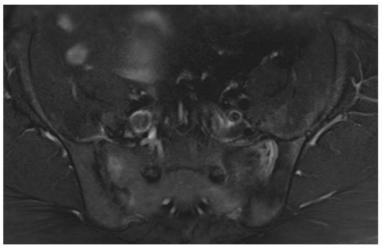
Serial MRI show improvement in the size of the collection and SI joint fluid.
